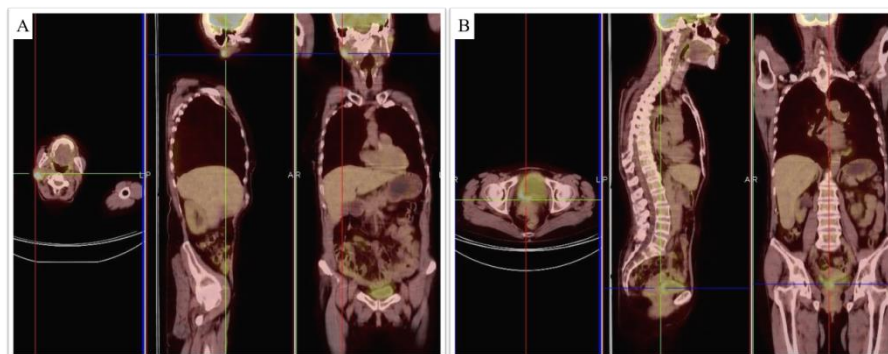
High-grade urothelial carcinoma of the bladder was diagnosed synchronously with Warthin tumor; A. Two foci with SUV_{max} were 11 and 4 in the right parotid, and a single focus with SUV_{max} was 7 in the left parotid. B. Increased FDG uptake with SUV_{max} of 8 was observed in wall thickening areas, more prominently in the posterior bladder wall.
